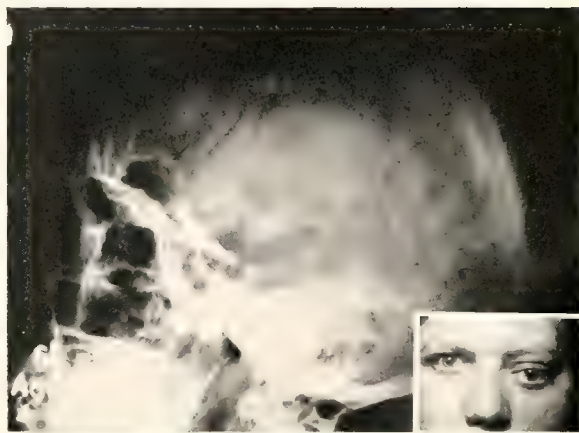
(Case 1). Extradural diploic epidermoids. The roentgenogram shows sharp scalloped erosion in the supra-orbital region.
